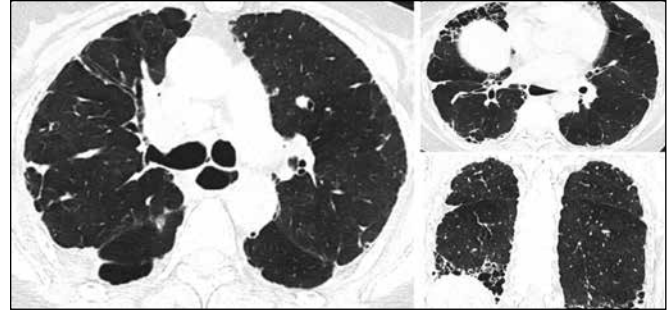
A 61-year-old female systemic sclerosis patient. HRCT (axial and coronal reformatted images) showing peripheral and patchy consolidation with bronchiectasis. In the lower sections inter-lobular septal thickening with honey-combing are also seen. Oesophagus is dilated. This was categorised as organising pneumonia. Features of UIP are also present.
